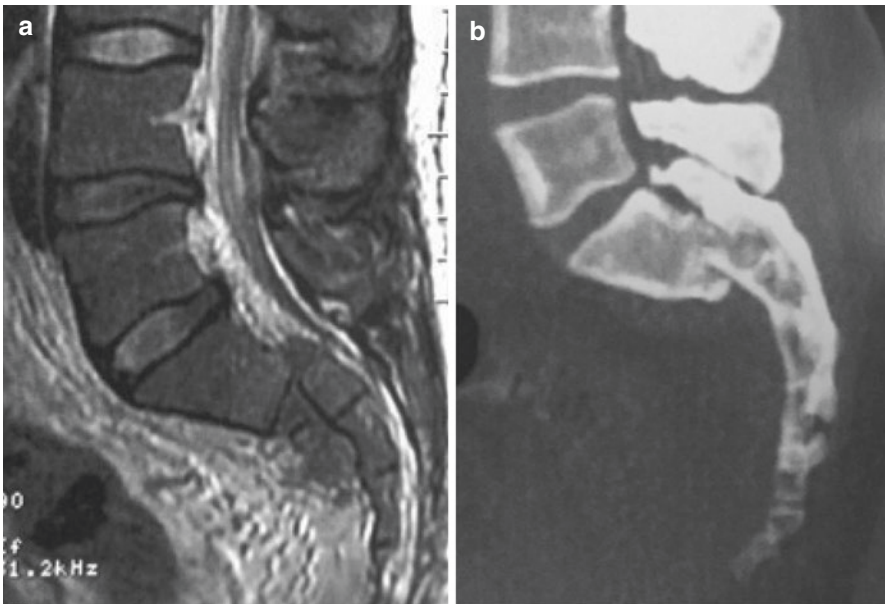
Type C3 injury; the information was given by MRI (a) is less precise than the one provided by the CT scan (b) which should guide the treatment algorithm
